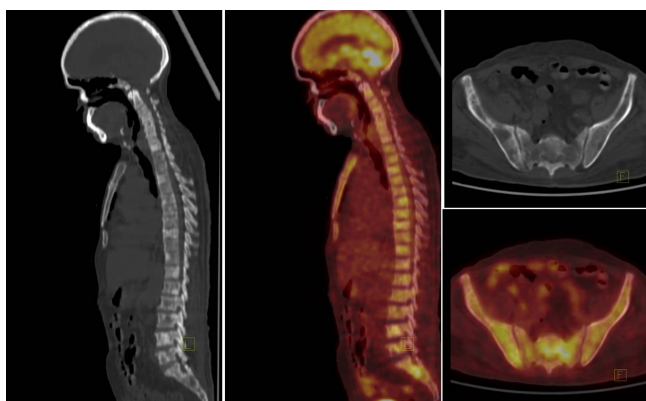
Moderately increased FDG concentration (SUVmax 6.3) noted in lytic-sclerotic lesions and bone marrow lesions involving multiple bones, highly suggestive of disseminated metabolically active disease, supporting the diagnosis of systemic malignancy.
